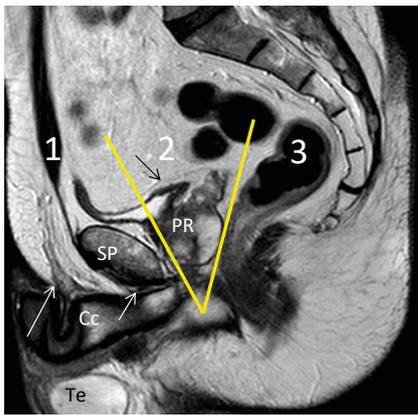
Midsagittal T 2-w TSE MR image of the male pelvis for subdivision into three compartments by two planes (yellow lines) tangent the anterior and posterior aspect of the prostate, respectively: 1= anterior; 2= middle; 3= posterior; SP = symphysis pubis; Cc = corpus cavernosum; Te = testis; thin black arrow= supra bladder peritoneal reflection; long white arrow= fundiform ligament; short white arrow = suspensory ligament of penis.
